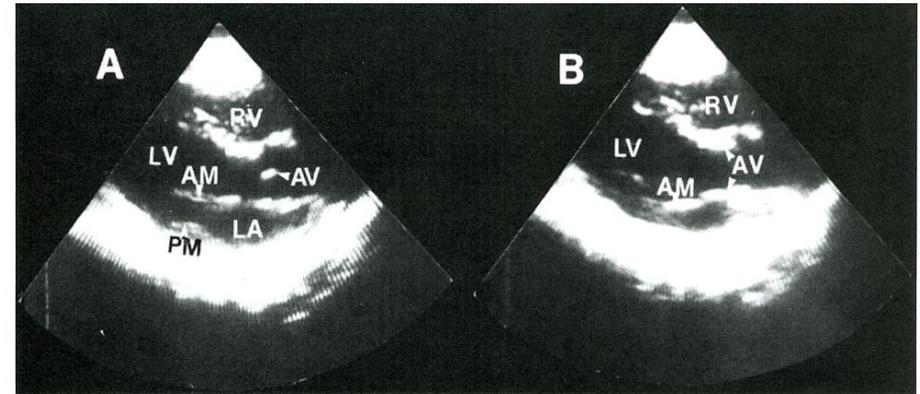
Long-axis 2-D echocardiographic images of the left ventricle (LV), right ventricle (RV), mitral valve, aortic valve, and left atrium (LA) during diastole (A) and systole (B). During diastole the anterior (AM) and posterior (PM) mitral leaflets are apart and the aortic valve leaflets (AV) come together as a single echo in the midportion of the aorta (A). With systole (B), the mitral leaflets come together and the aortic valve leaflets separate.
